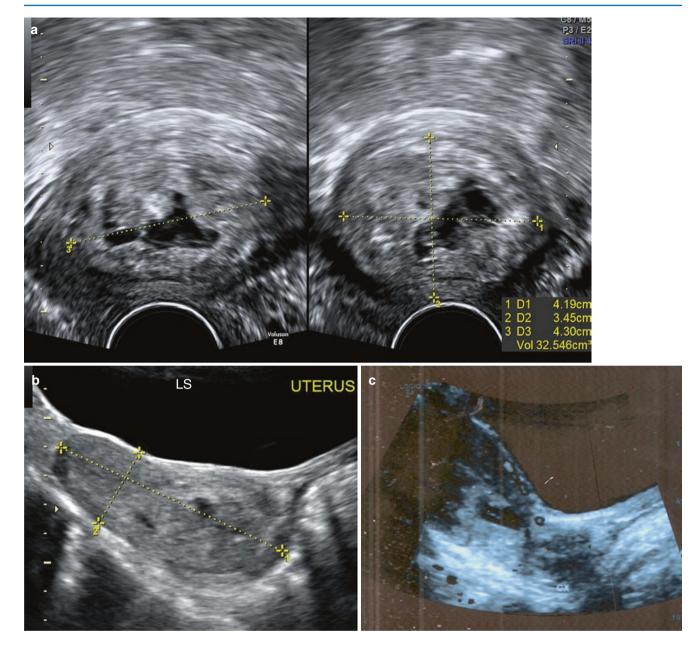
Patient presented with heavy bleeding. (a) Ectopic pregnancy mass seen in the cervix with thick trophoblastic tissue and a central, irregular cystic space suggestive of a gestational sac. (b) TAS- the uterine body appeared normal and the cervix was ballooned out, showing trophoblastic tissue within. (c) Scanned image of the patient's previous report (done elsewhere a few days earlier) which shows a GS in the lower uterine cavity and a normal-appearing cervix. (d) On careful examination, it was seen that there was a thick vascular channel supplying the trophoblastic tissue from the posterior wall of the uterus at the midcorpus. From the image of the previous scan, it was easy to confirm that though this appeared like a cervical ectopic pregnancy, it was a case of inevitable abortion and was easily managed with surgical evacuation. (e) Vascular pedicle (*small arrows*) of the trophoblastic mass seen on greyscale and Doppler from the posterior myometrium, with the endometrium anterior to it (*long arrow*) appearing normal
